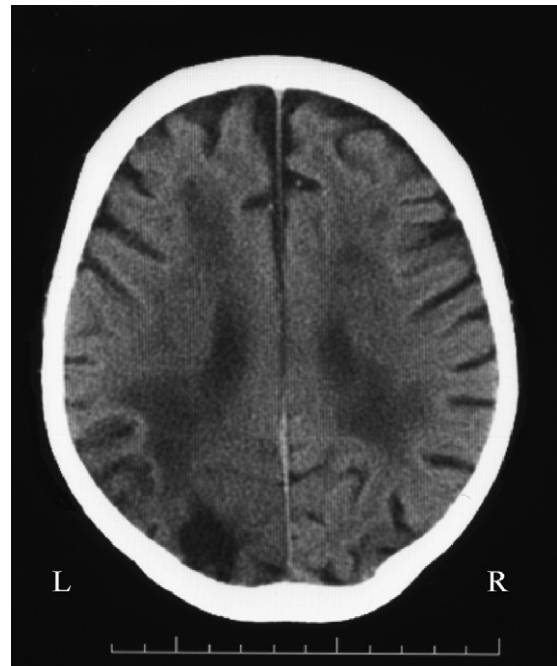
A CT transversal slice showing the extent of lesion in DBO's occipital area.
